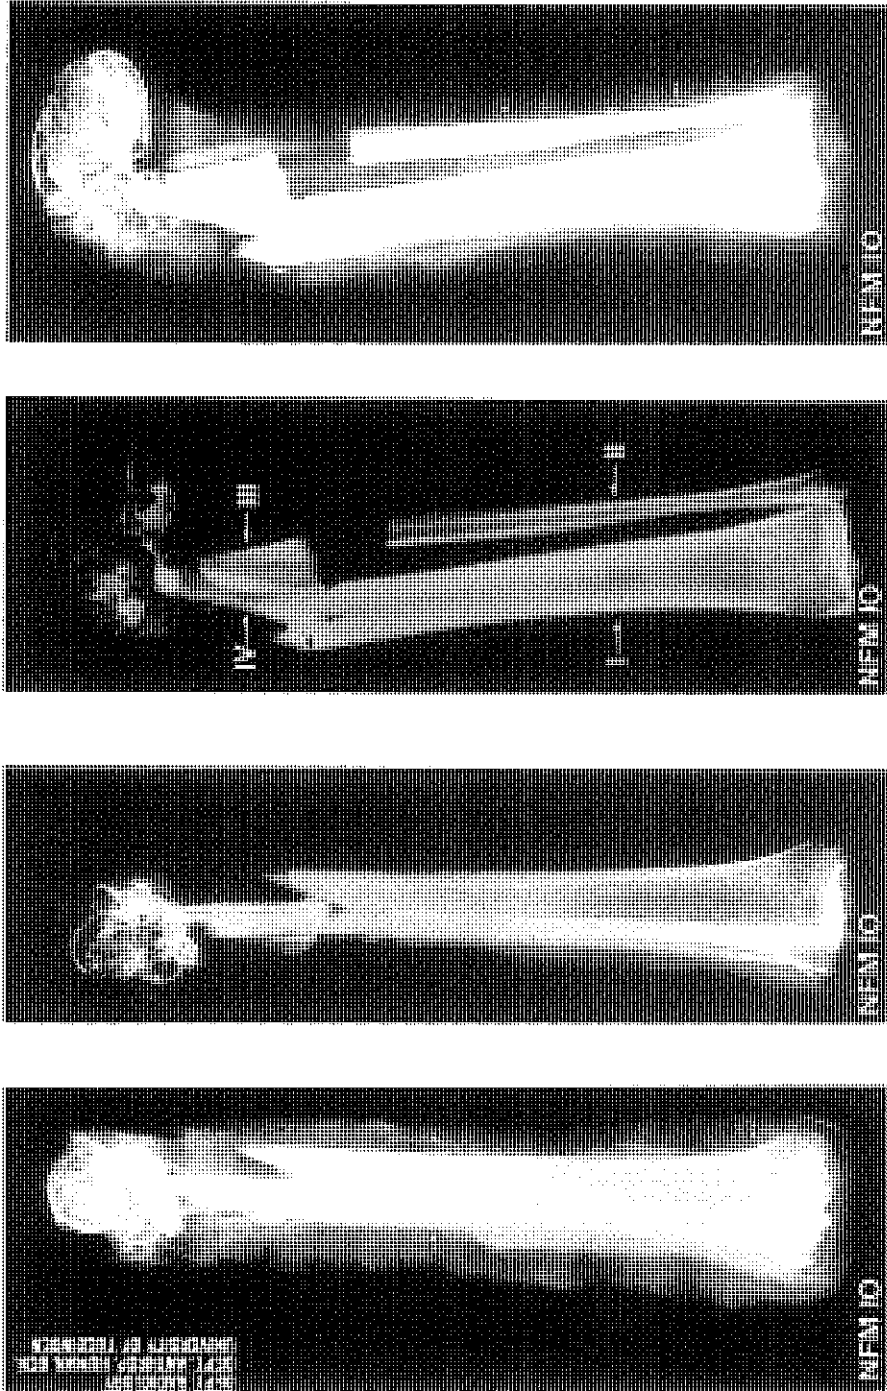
a) Radiograph showing the arrangement of bandages (a p projection). Fragment I (cf. Fig.c) must have been covered by skin when it was bandaged (slight layer of soft tissue on the bone indicated by arrows) b) a p -projection demonstrating the structure of the proximal part of the tibia c) Right lateral projection indicating the different fragments of bone (I-IV). Black arrows: possible joining of fragments done by the mummification priests
